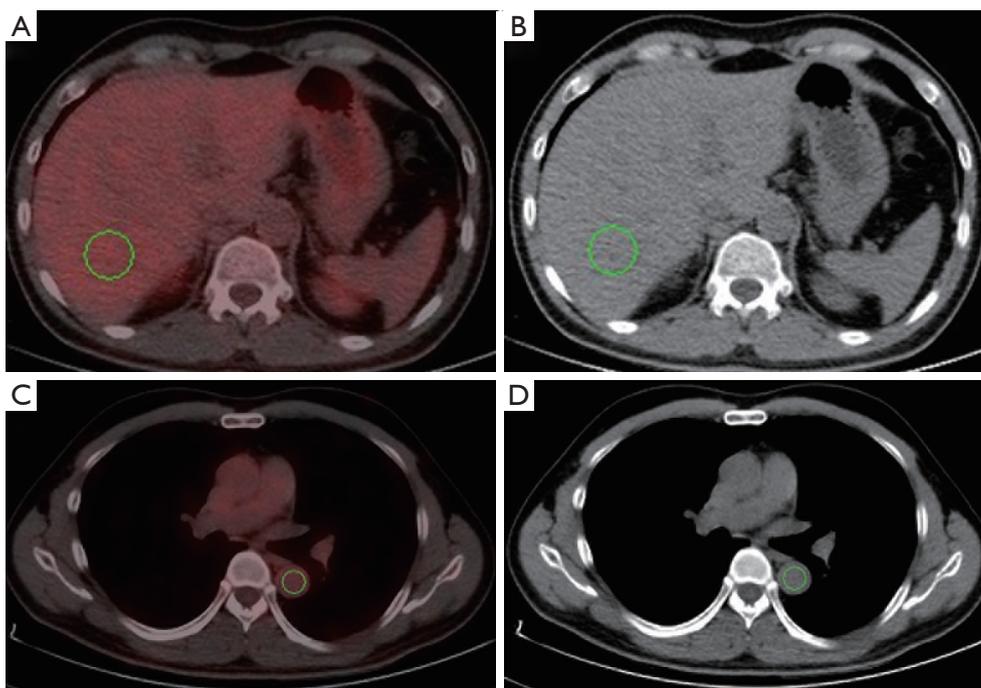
Images of a 40-year-old man with no cancer history. PET/CT was performed for physical examination. (A) The fusion image showed an ROI with a diameter of 3 cm in the center of the right lobe of the liver. (B) The CT images showed a liver of normal appearance with no sign of abnormalities. (C) The fusion image showed an ROI inside the thoracic aorta at the carinal level. (D) The CT images showed a blood pool of normal appearance with no sign of abnormalities. PET/CT, positron emission tomography/computed tomography; ROI, region of interest.
